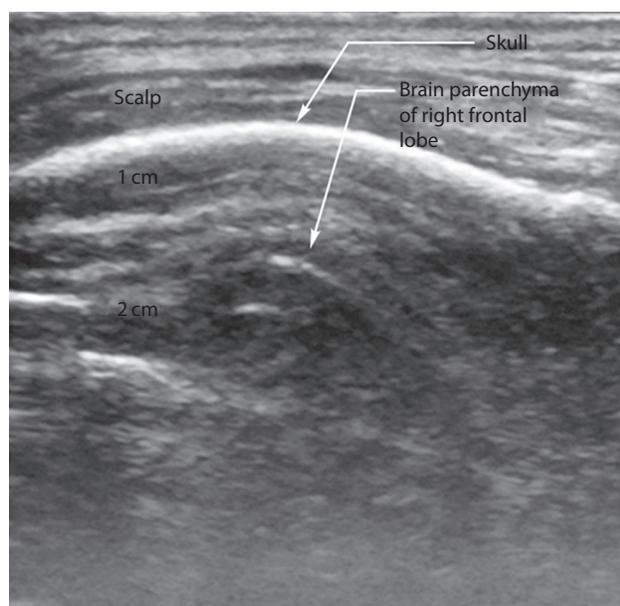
Example of image taken from a chronic pain patient. Longitudinal gray scale images taken from a session of transcranial ultrasound. Scalp, skull, and brain tissue are visible in the image. (Adapted with permission from Hameroff S et al. *Brain Stimul* 2013;6(3):409–15.)
